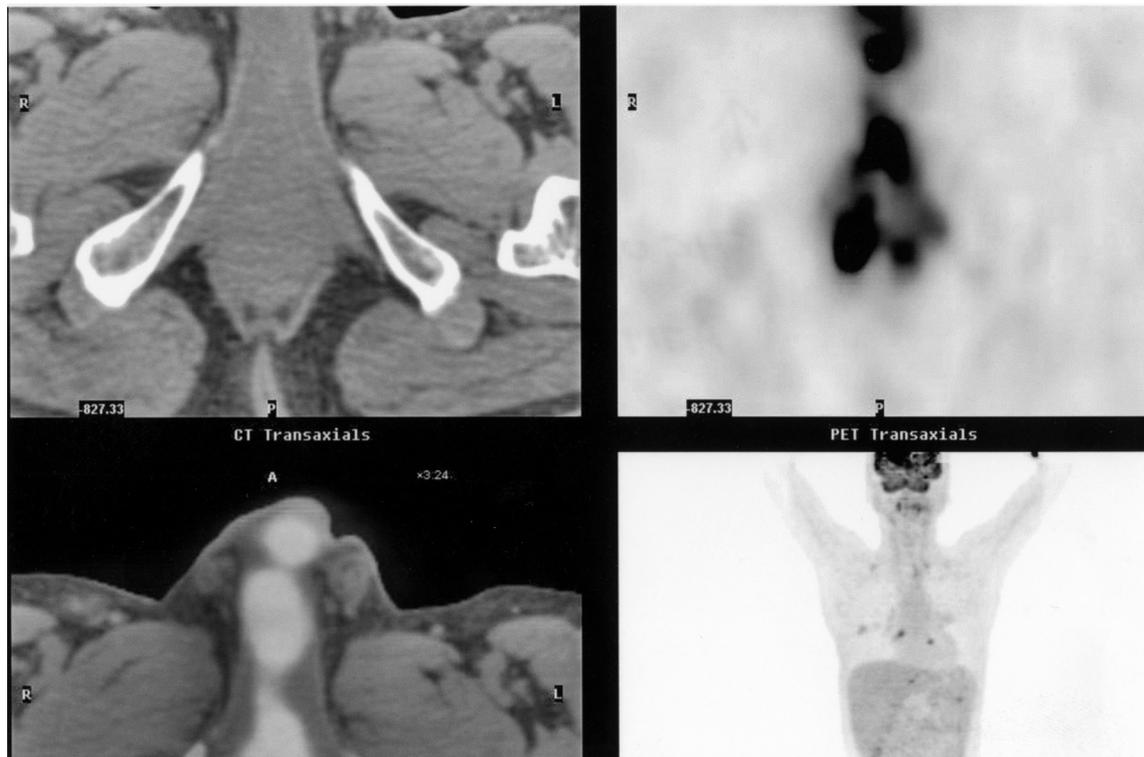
Coronal positron emission tomography-computed tomography (PET-CT) fusion images showing uptake along the penis, indicating recurrent disease.
